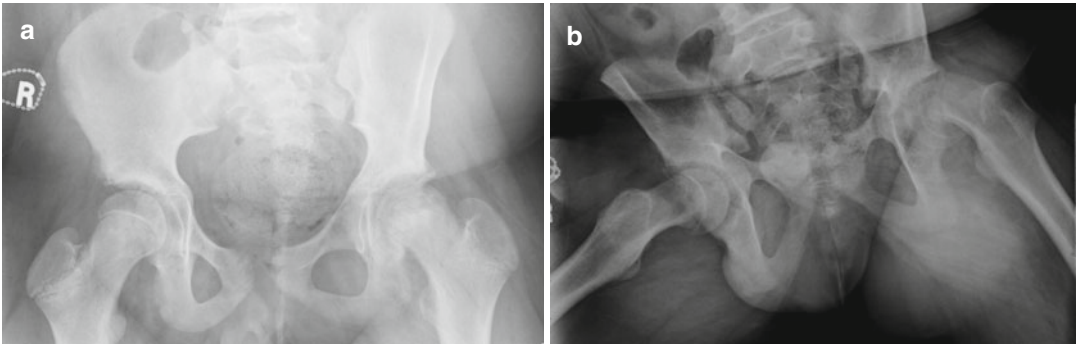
AP (a) and frog-lateral radiograph (b) of a typical patient with a stable SCFE, presenting with several
